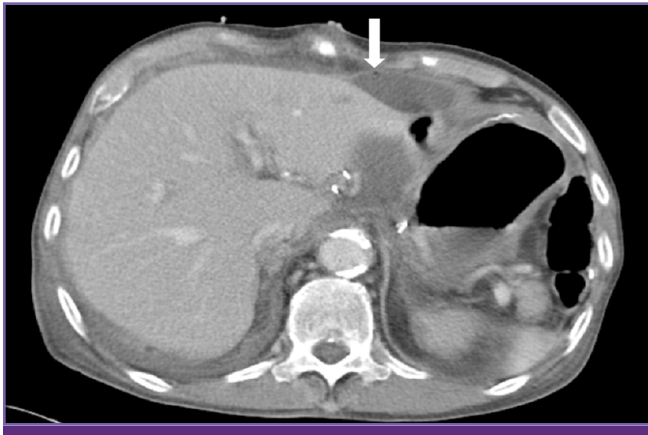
CT on abdomen showed complicated fluid collection with a small amount of air bubble (arrow) around the operation site.
